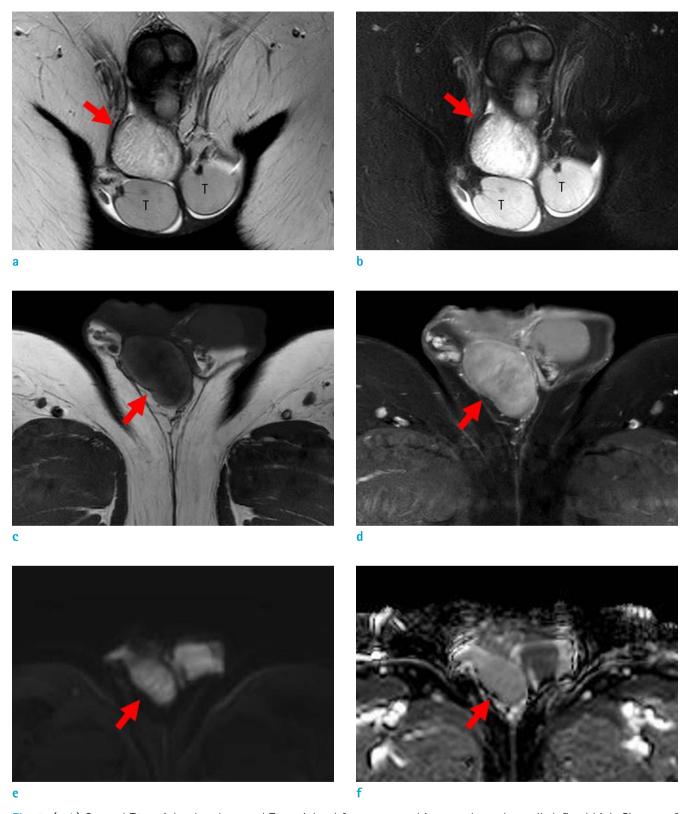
(a, b) Coronal T2-weighted and coronal T2-weighted fat-suppressed images showed a well-defined high-SI mass of about 4.5 cm, without fat suppression (arrows) (T: testis). (c, d) An axial T1-weighted image revealed a low-SI mass, with heterogeneous enhancement (arrows). (e, f) DWI showed no diffusion restriction at the right suprascrotal mass (arrows).
